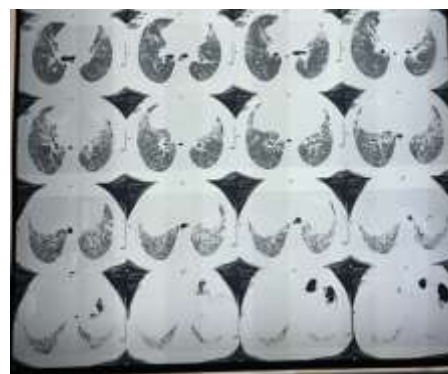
CT Thorax showing progressive fibrosis, Honey combing
